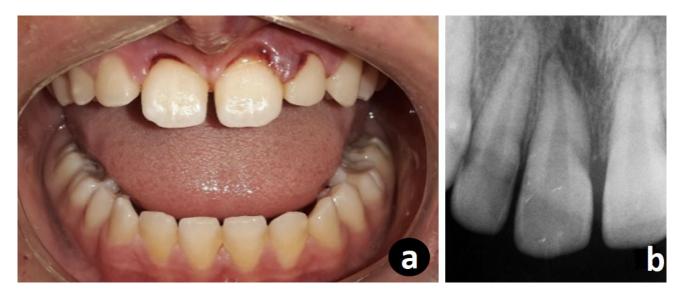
a: Preoperative view of Case 2. b: Preoperative radiograph showing horizontal fracture in the apical-third of the root of the tooth #21.
